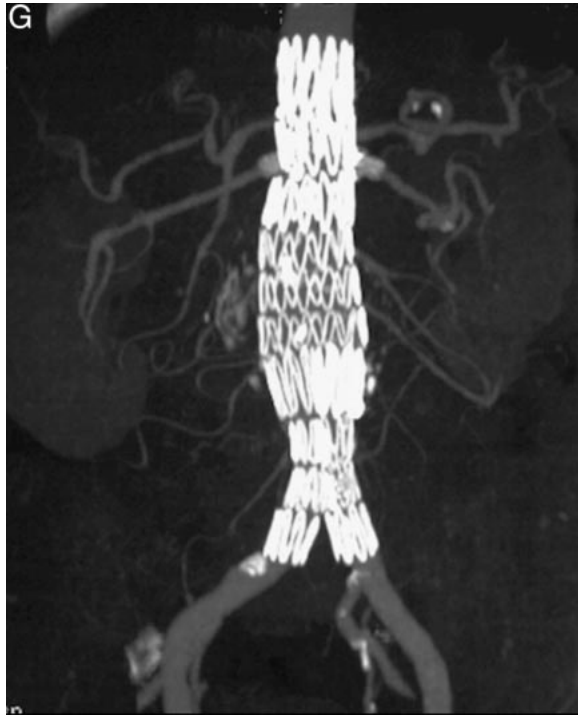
continued. ♦ Both renal arteries are well perfused (G), and the modified P204 stents are clearly seen protruding beyond the metallic framework of the graft. Subsequent computed tomographic scanning at 7-month follow-up has shown an excellent seal, with continued perfusion of all vessels. In the axial view (H), the patency of the renal vessels is easily verified. Note that there is also preservation of the hypogastric artery.
